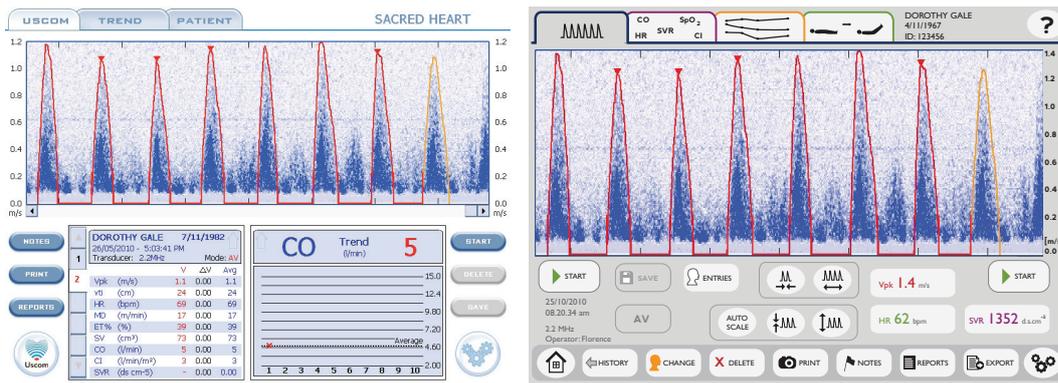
Left: Current screenshot of Examination screen. Right: Fictional screenshot of the Doppler profile screen (previously Examination screen).
